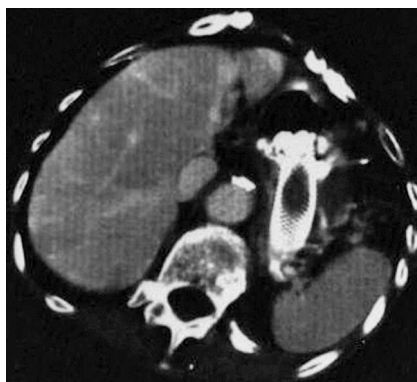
Restaging computed tomographic scan of the abdomen showing a migrated esophageal self-expanding metallic stent in the stomach.
